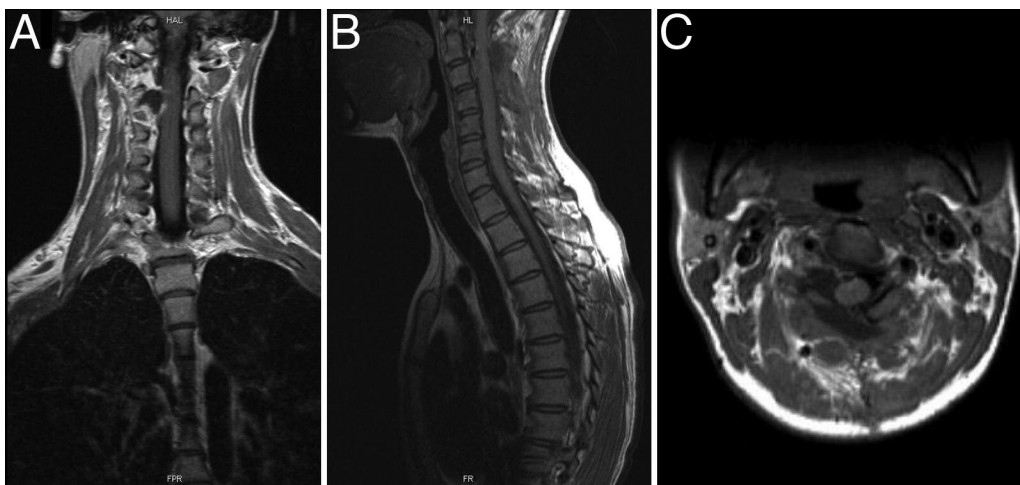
Postoperative coronal (A), sagittal (B), and axial (C) T₁-weighted MR images obtained 6 months after surgery showing the gross-total removal of the lesion.
